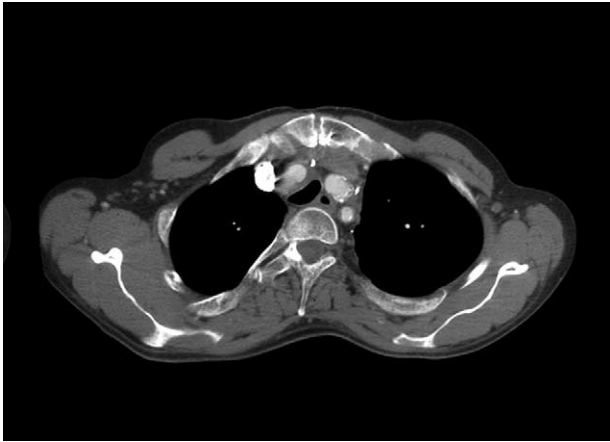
CT scan of the cervical region 5 months after exclusion of the innominate artery aneurysm and construction of new bypasses to the right carotid and subclavian artery. Persistent tracheomalacia with a diameter reduction of approximately 60% is visible.
